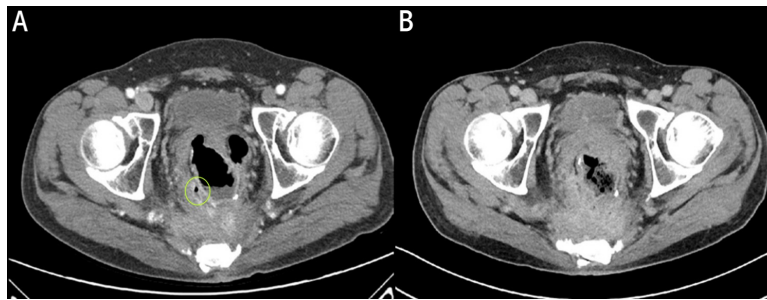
Comparison of abdominal computed tomography.
